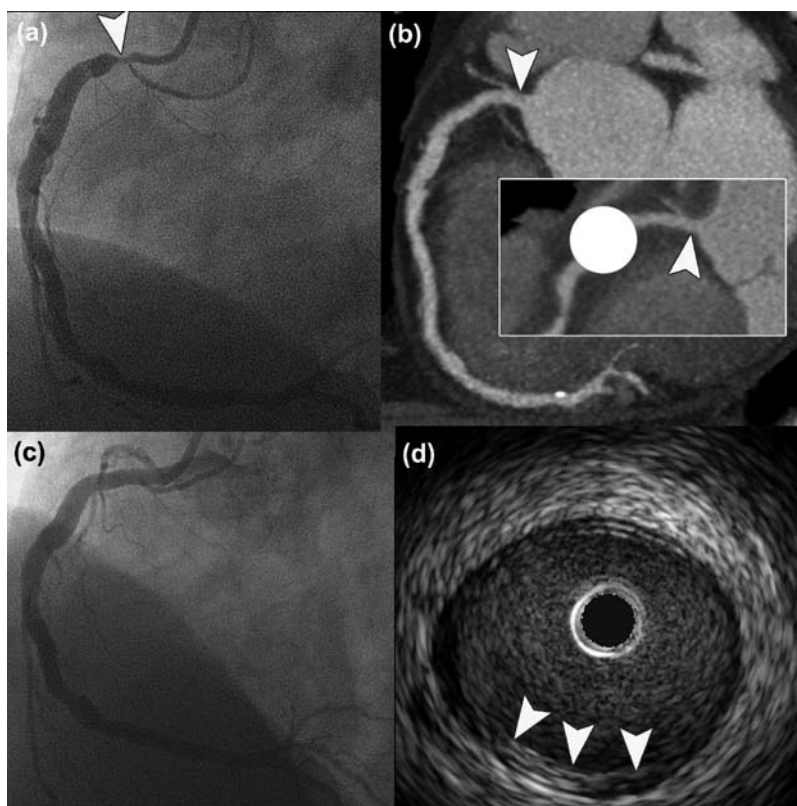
Patient who was referred to undergo a percutaneous coronary intervention for an ostial stenosis of the right coronary artery. (a) Initial angiographic image showing the coronary narrowing (arrowhead). (b, with inset) On cardiac CT the vessel had a normal appearance. (c) A repeat coronary angiogram confirmed the CT findings. (d) On intravascular ultrasound the ostium was indeed widely patent with only minimal intimal thickening (arrowheads).
